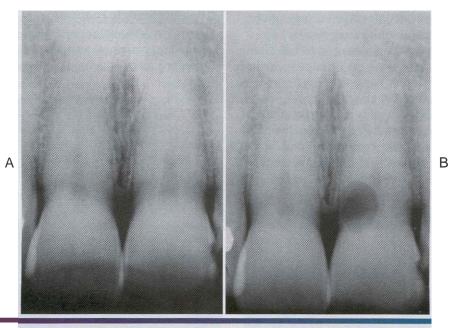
• Cervical external resorption. A, Radiograph of anterior maxilla exhibiting no Significant areas of resorption. B. Well-defined radiolucent alteration of the cervical area noted three years after initial radiograph. (Courtesy of Dr. H. Dwaine Blakeman.)
